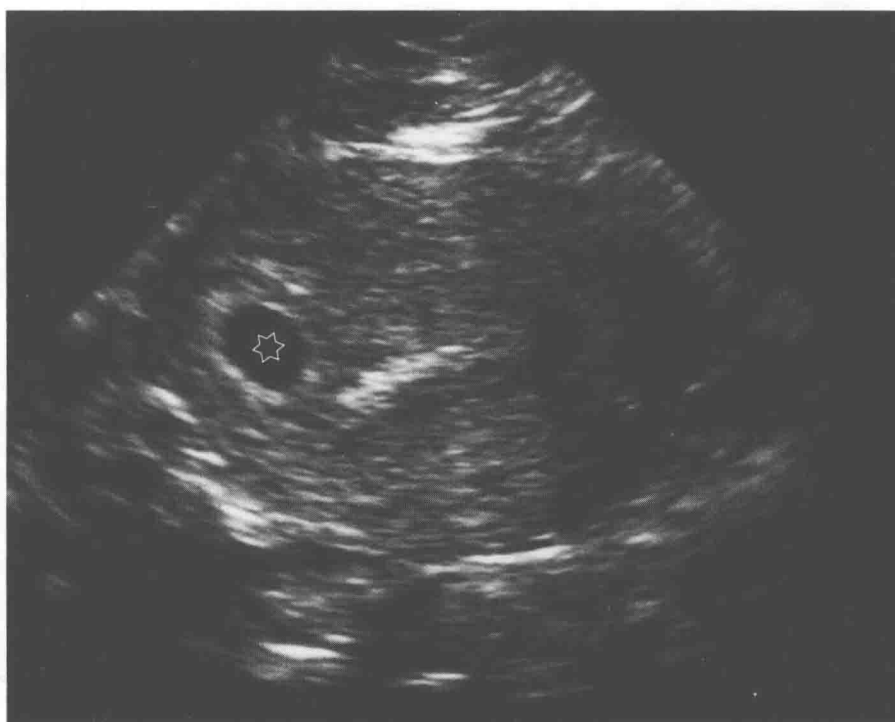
Transverse view of the fundus of the uterus showing an eccentrically placed but normal gestational sac (*). This type of sac position raises the question of cornual or interstitial pregnancy. A portion of myometrium should lie lateral to the sac. If no myometrium is present, an interstitial pregnancy becomes more likely. A bicornuate uterus can also give rise to an eccentric position of the gestational sac; there is a split endometrial cavity with a second decidual reaction in the opposite horn. Fibroids may displace the sac into a lateral position. The fibroid should be visible. In this instance, later ultrasound studies showed a normal position of the sac.
